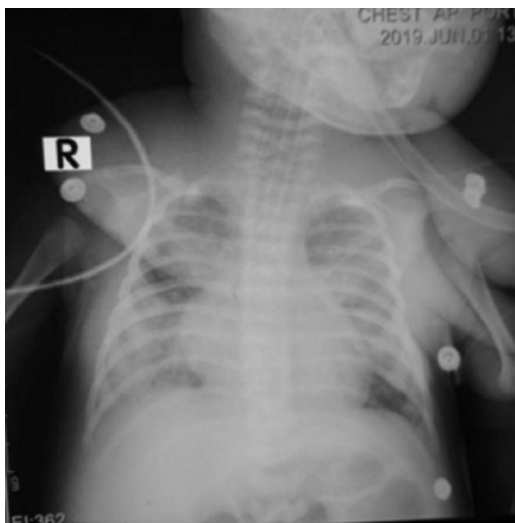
X-ray Chest showing B/L diffuse opacity involving all 4 zones
